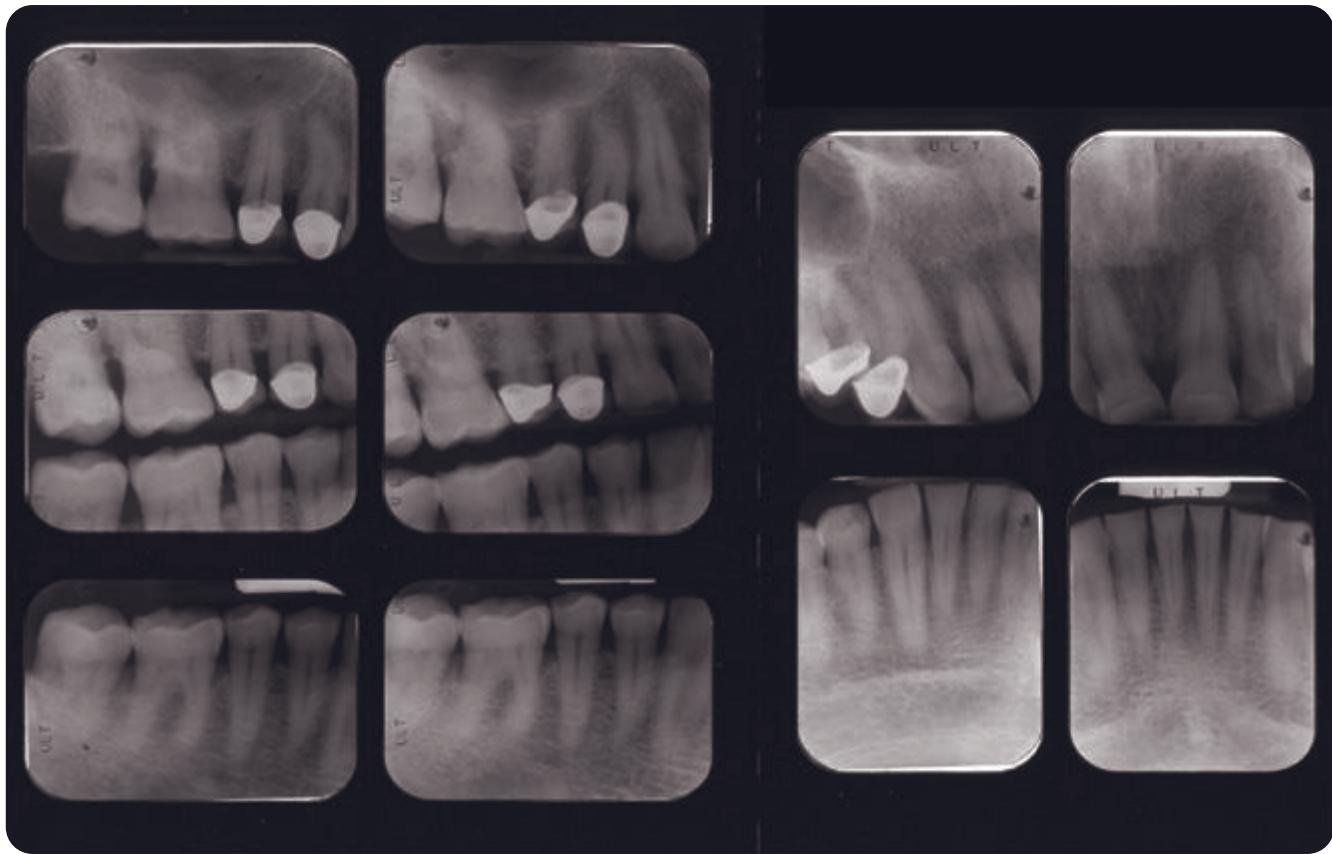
Pretreatment radiographs, right side.¹
